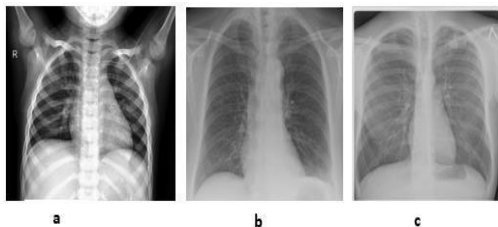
Three conditions of Chest X-ray images: a) Normal, b) COVID-19 and c) Tuberculosis.
